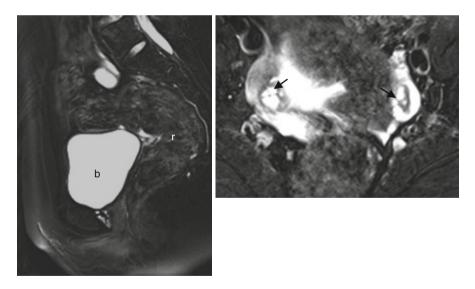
Congenital absence of the uterus and vagina syndrome (Mayer-Rokitansky-Kuster-Hauser syndrome, MRKH syndrome). The *left* is fat-saturated sagittal T2-weighted image showed the complete absence of the cervix and uterus. Between the rectum (*r*) and bladder (*b*), normal vagina is invisible. The *right* is an axial T2-weighted image showing bilateral normal ovaries (*black arrows*)
